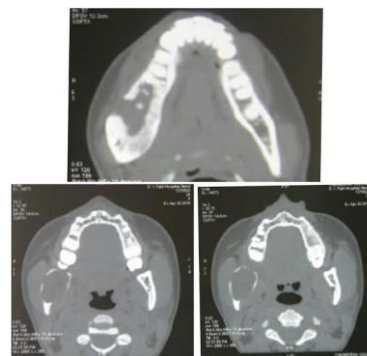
Axial CT sections
